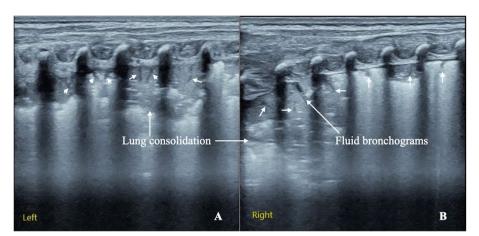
Invasive MV should be implemented as quickly as possible for Pulmonary hemorrhage. Examination of the lung showed large area of lung consolidation with air bronchograms (the highperechoic reflection within consolidation area), fluid bronchograms (the linear hypoechoic reflection within the consolidation area) and shred signs (the highperechoic reflection on the edge of consolidation area) in both lungs (A: left lung, B: right lung), which are consistent with ultrasound imaging findings of pulmonary hemorrhage. The invasive MV should be implemented as soon as possible in this case
